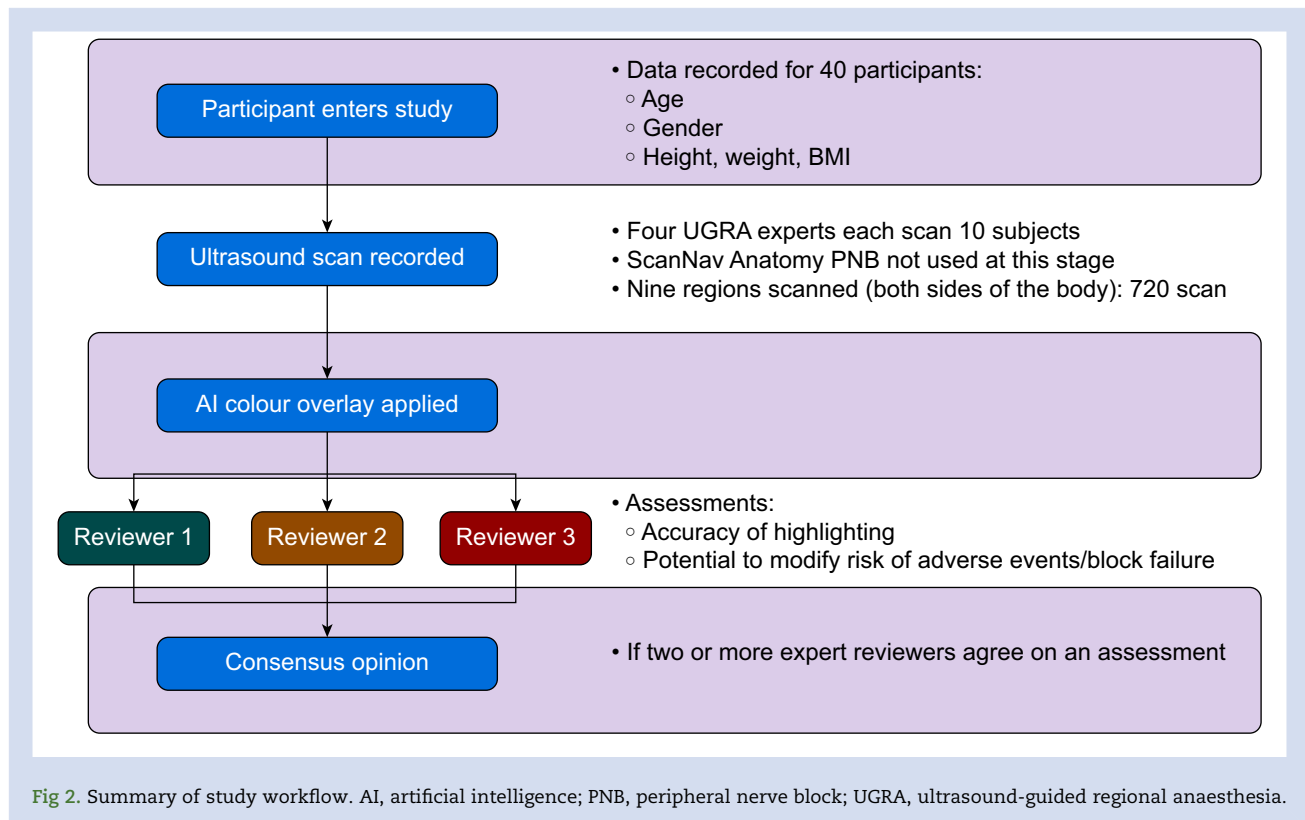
Summary of study workflow. AI, artificial intelligence; PNB, peripheral nerve block; UGRA, ultrasound-guided regional anaesthesia.
